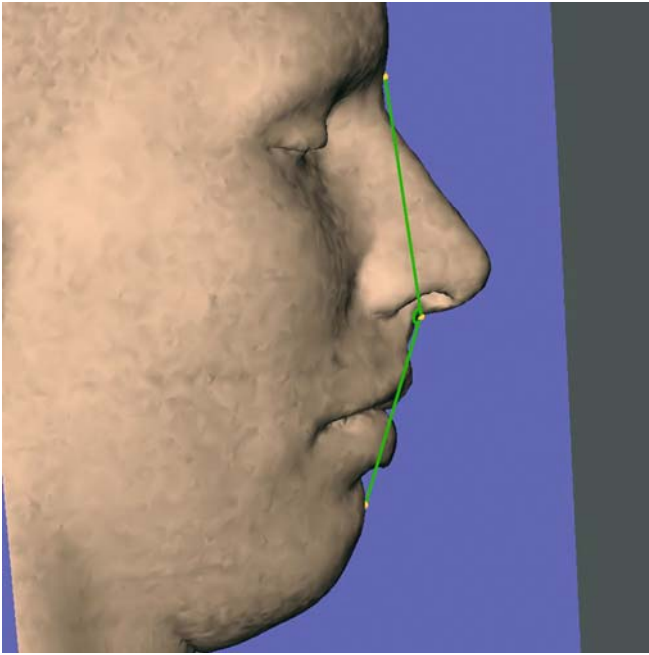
The soft tissue convexity angle, n-sn-pg, is a projected angular soft tissue measurement on the median (z) 3-D cephalometric reference plane (3-D CT, soft tissues, patient K.C.)
